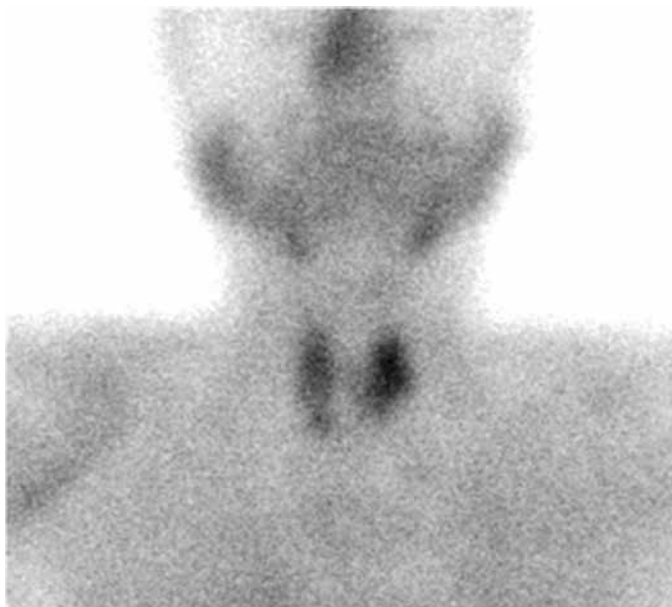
Tc-99m-sestamibi parathyroid scintigraphy of the patient
